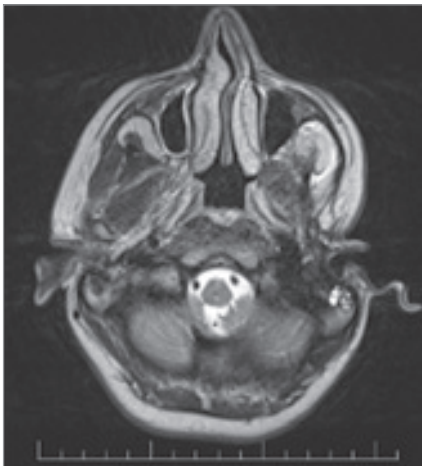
Postoperative MRI – first case.
